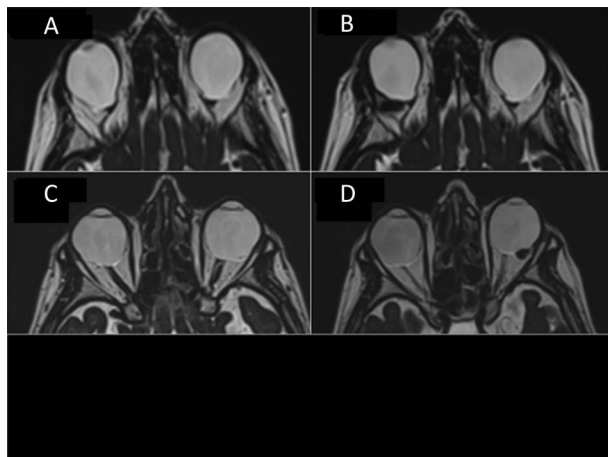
A. T2 TSE axial magnetic resonance images of the orbits. The posterior contour of both globes is deformed in a macular and papillary staphyloma. B. T2 TSE axial magnetic resonance of the same patient, 1 month after the macular buckle implantation. The posterior wall of the right eye is flattened by the macular buckle. C. T2 TSE axial magnetic resonance images of the orbits of a different patient. The posterior contour of both globes is deformed in a macular staphyloma. The left eye, observed from the bottom, has a macular detachment. D. T2 TSE axial magnetic resonance of the patient in Figure 8C, 1 month after the macular buckle implantation. The posterior wall of the left eye is slightly convex on the macular buckle.
